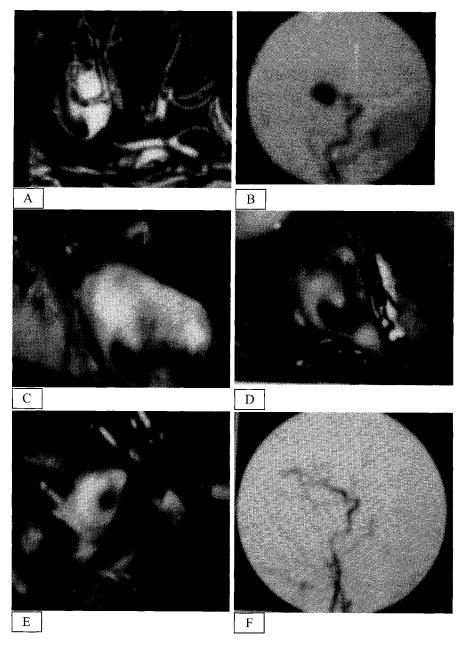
A patient of middle cerebral artery aneurysm presented with grade-1 subareachnoid haemorrhage. A 3D CT scan and B DSA done revealed a giant aneurysm of the MCA bifurcation. He was subjected to microsurgery. C Intraoperatrively the aneurysm neck was found to be atherosclerotic with thickened walls. D,E The aneurysm was clipped with the help of 2 clips. F Postoperative angiogram revealed complete obliteration of the aneurysm
